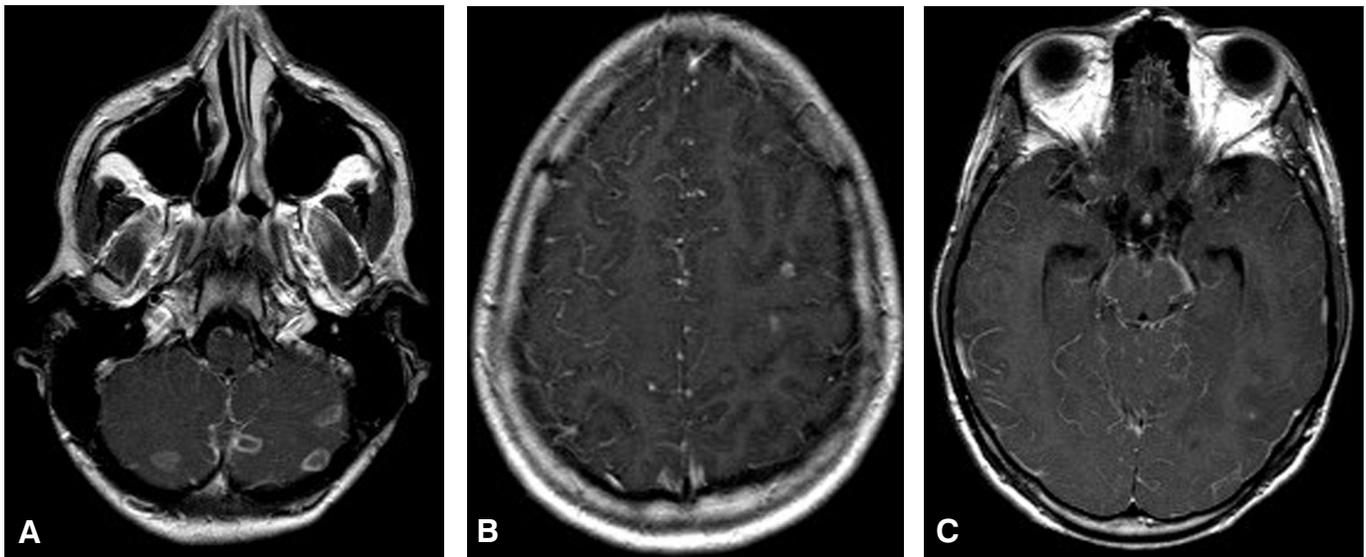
Contrast-enhanced T1-weighted axial MR images showing (A) multiple ring-enhancing lesions in the cerebellum, (B) multiple enhancing cortical granulomas, and (C) perimesencephalic leptomeningeal enhancement consistent with basilar meningitis.
